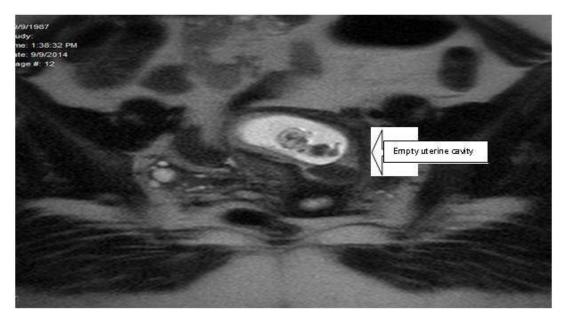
MRI showing cornual pregnancy with empty uterine cavity
